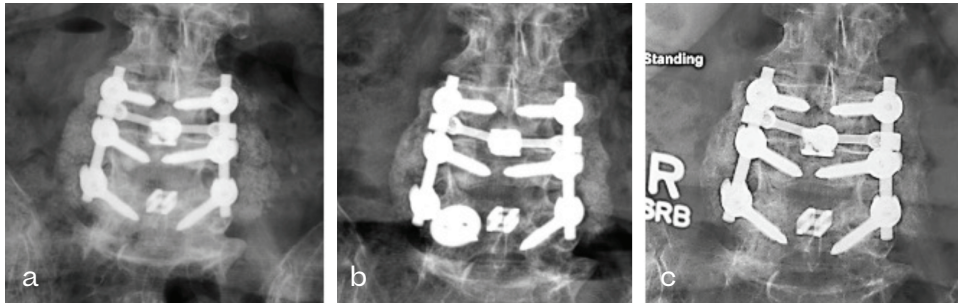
Comparative AP X-ray radiographs of patient #7 at 3 months (a), 6 months (b), and 12 months (c) following L4-5, L5-S1 posterolateral fusion. There is notable progression of posterolateral bony fusion over the 12-month period with robust solid posterolateral bony fusion at 12 months.
